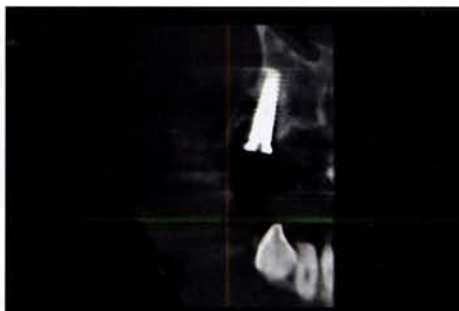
Green CT (VaTech America) post-operative view of surgical site and dental implant
